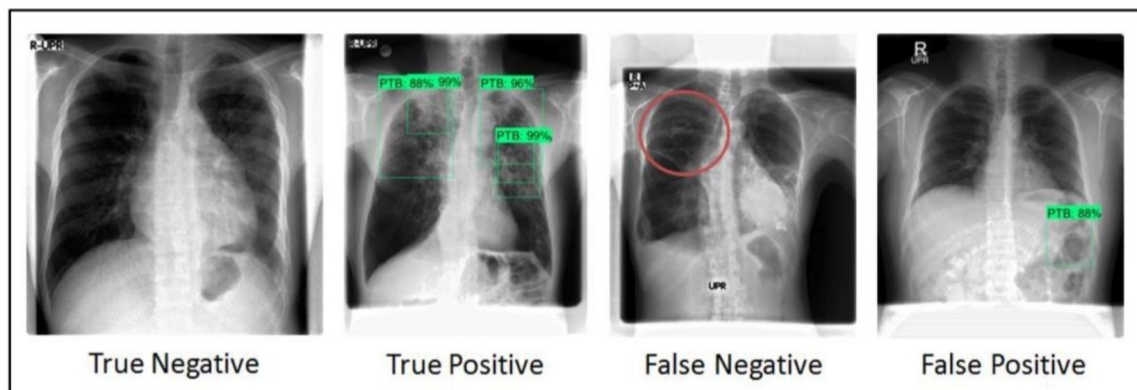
Sample radiograph for classification for analysis as a locator.
